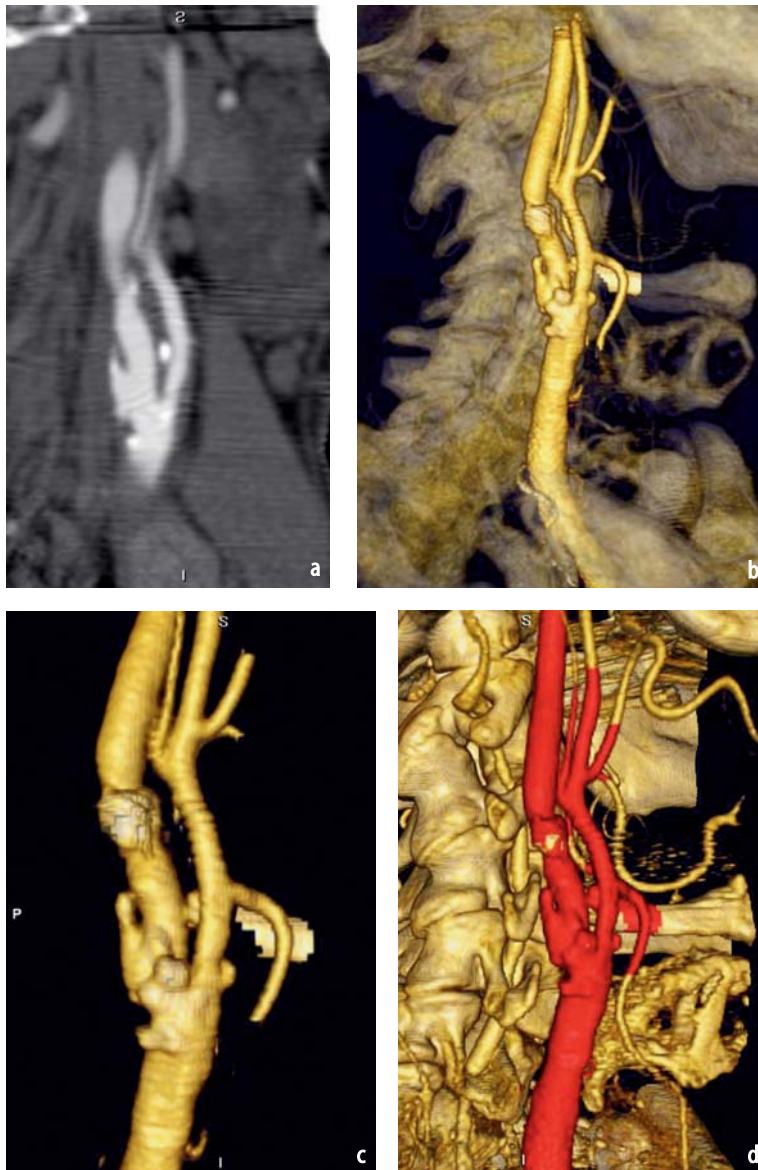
Carotid vascular disease on CTA. a Sagittal reformatted maximum intensity projection (MIP) demonstrates undermined, ulcerated plaque with moderate stenosis. b Volume-rendered surface-shaded three-dimensional (3-D) image of moderate stenosis and ulcerated plaque shows calcified plaque. c Magnified image with deleted background better exhibits carotid bifurcation region. The calcified plaque is lighter in this scheme, and the ulceration is well depicted posteriorly. d Automated vessel definition using a red color scheme example. Note the calcifications are not differentiated in this particular method
